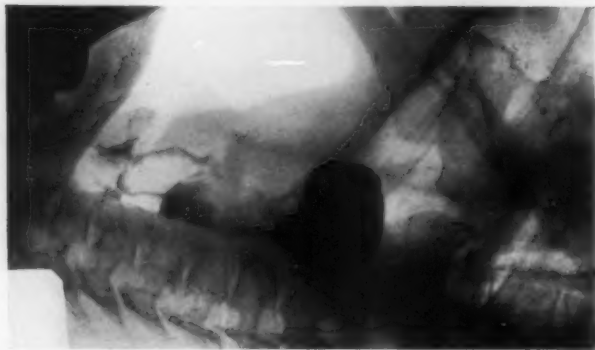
Roentgenogram made in the lateral plane after swallowing barium while dorsally recumbent exhibits a large collection of the material in the pouch lying behind the esophagus. This pouch communicates with the pharynx and its contents gravitate upward as soon as the pharynx becomes dependent. There is no sphincter surrounding the neck of the pouch. During sleep, with the head low, the contents of the pouch, gravitating into the pharynx, often are aspirated into the trachea.
